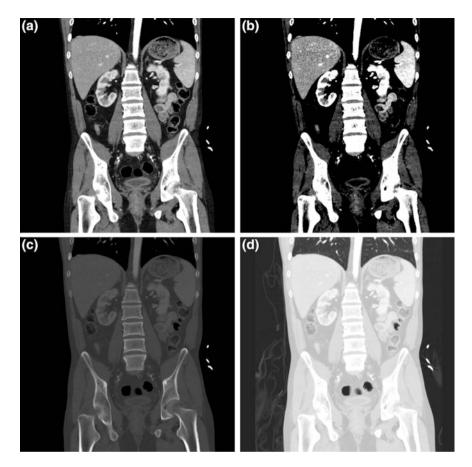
Abdominal CT image set to different clinical read out windows. Coronal plane image from a CT study of the abdomen and pelvis delineating detail of multiple abdominal organs, in a general soft tissue window (here, w = 400, l = 60); b "hard contrast" soft tissue window setting (here, w = 150, l = 88) for enhancing visualization of certain abdominal organs, c bone window setting for assessment of skeletal structures (w = 2,000, l = 500); and d lung window setting (w = 1,500, l = -500) to assess air or gas containing tissues with the body, such as lungs, and hollow visci
